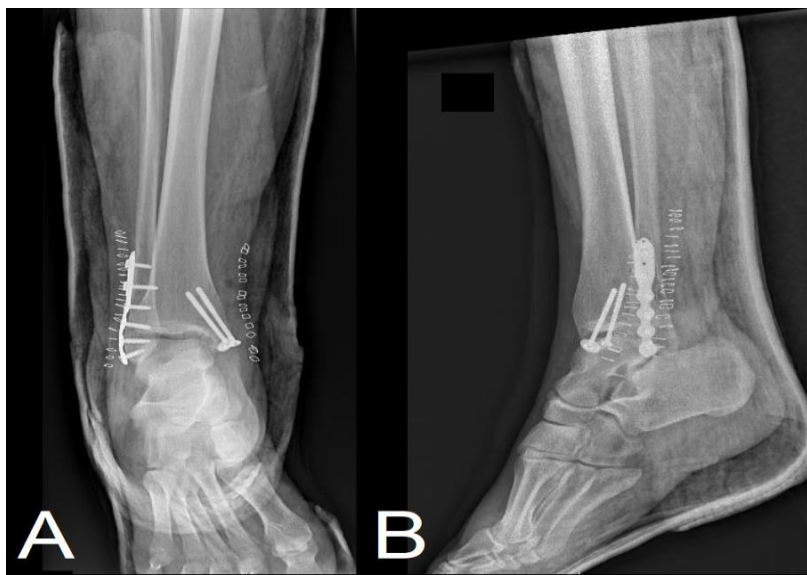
Anteroposterior (A) and Lateral (B) post-operative radiographs
